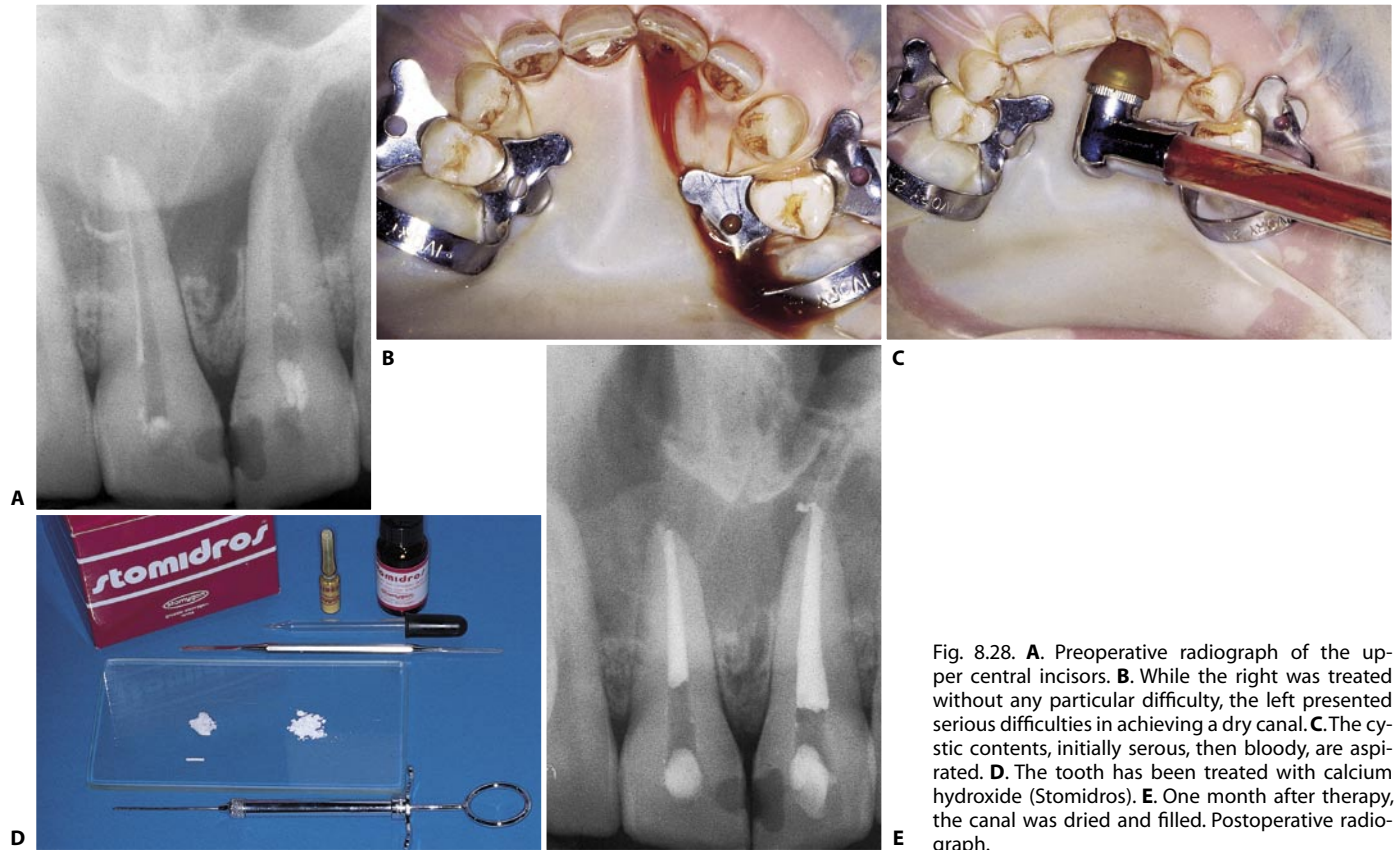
A. Preoperative radiograph of the upper central incisors. B. While the right was treated without any particular difficulty, the left presented serious difficulties in achieving a dry canal. C. The cystic contents, initially serous, then bloody, are aspirated. D. The tooth has been treated with calcium hydroxide (Stomidros). E. One month after therapy, the canal was dried and filled. Postoperative radiograph.
